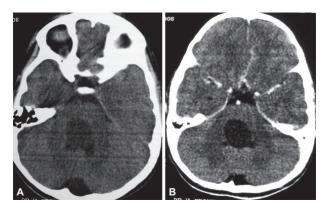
Pre operative CT scan images demonstrating an intra axial pontine epidermoid tumor. A: Non contrast computed tomogram (NCCT) image, B: contrast enhanced computed tomogram (CECT) image.
